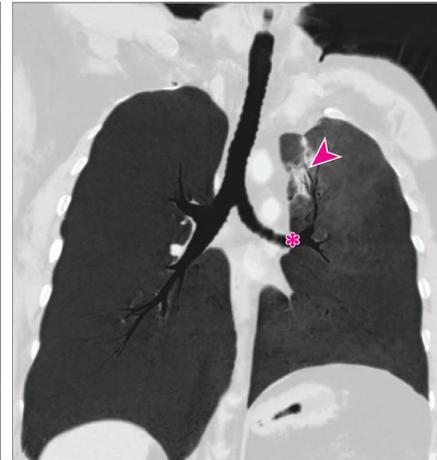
A, Suprasternal view of a transthoracic echocardiogram with an ultrasonic-enhancing agent, showing contrast in the descending aorta (arrowhead). Distal to the left subclavian artery, contrast fills the lumen. Increased echodensity with a round appearance and a narrow neck is shown (blue asterisk); there is an absence of contrast surrounding this round area, corresponding to a thrombus (white asterisk). B, Contrast computed tomography showing an aortic pseudoaneurysm distal to the left subclavian artery (arrowhead). C, Computed tomography pulmonary window showing pulmonary sequestration (arrowhead) near to the left bronchus (asterisk).
